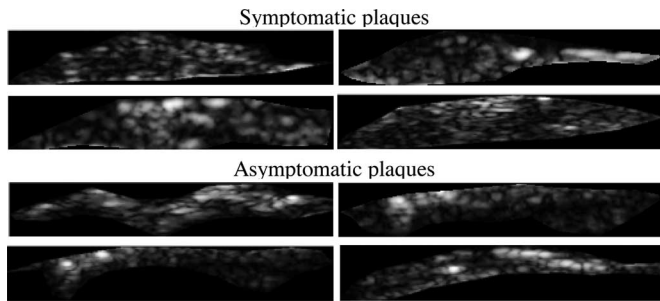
Examples of plaque ROIs manually segmented from B-mode ultrasound images for symptomatic and asymptomatic plaques. Examples correspond to a systolic (left) and diastolic (right) phase of the cardiac cycle.
